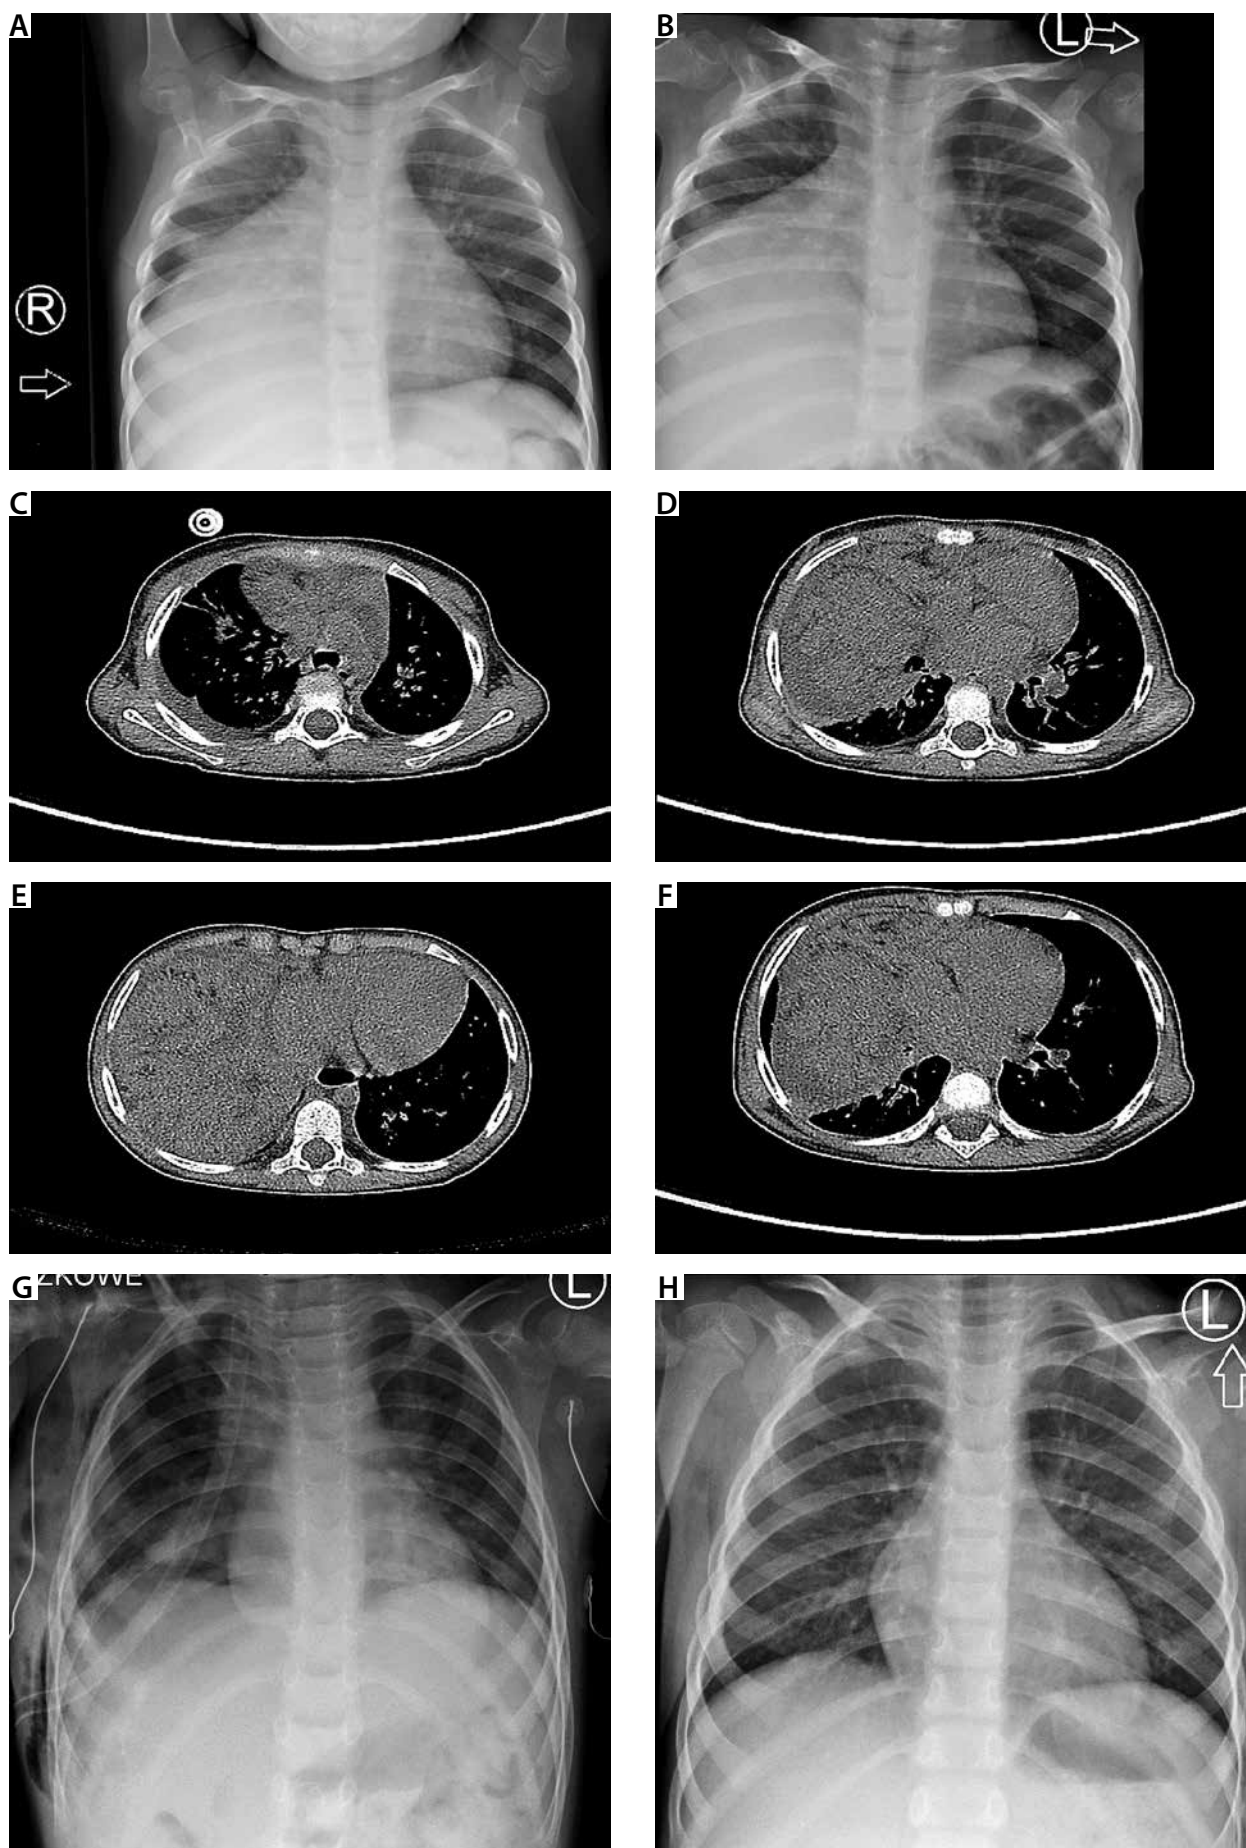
Image A) Chest X-ray performed upon admission. B) Chest X-ray performed on the ninth day of hospitalisation. C– F) Chest CT. G) Chest X-ray performed after surgery. H) Chest X-ray performed several months after surgery
